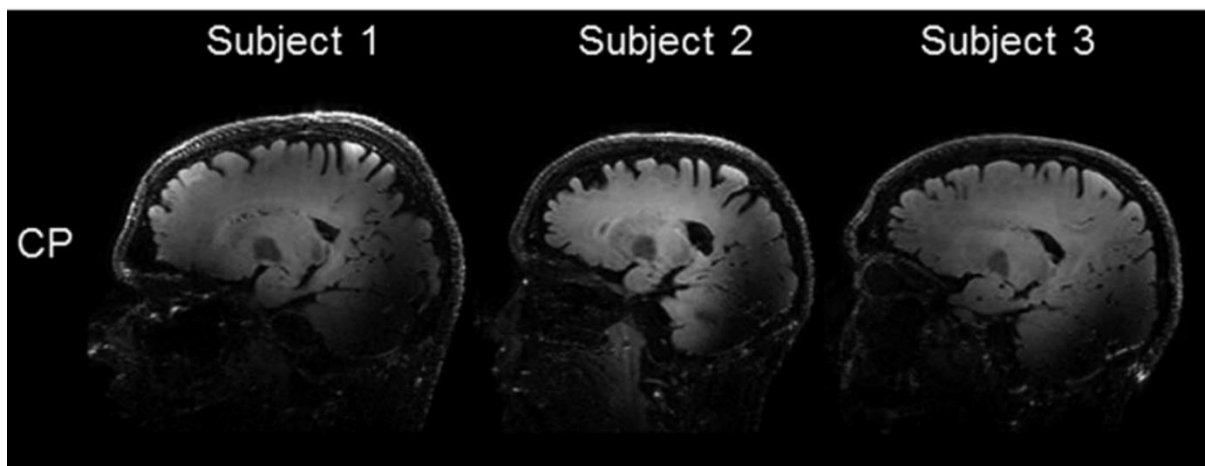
Sagittal image of a FLAIR-SPACE sequence acquired in CP mode at 7T. Reprinted from Gras et al. (17) with permission of John Wiley & Son, Inc.
